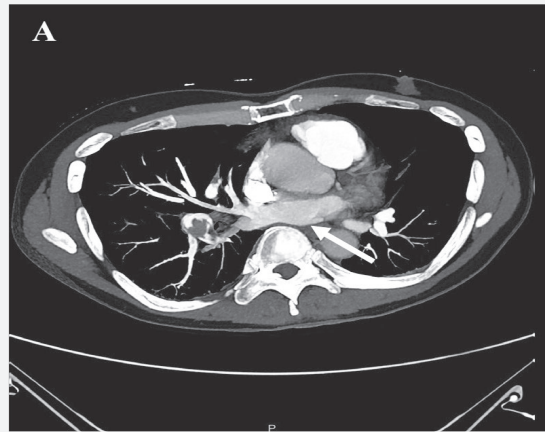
Computed tomography of the pulmonary artery showing multiple filling defects (white arrow) starting from the main pulmonary artery (A) and propagating to the right (B) and left (C) main pulmonary arteries
